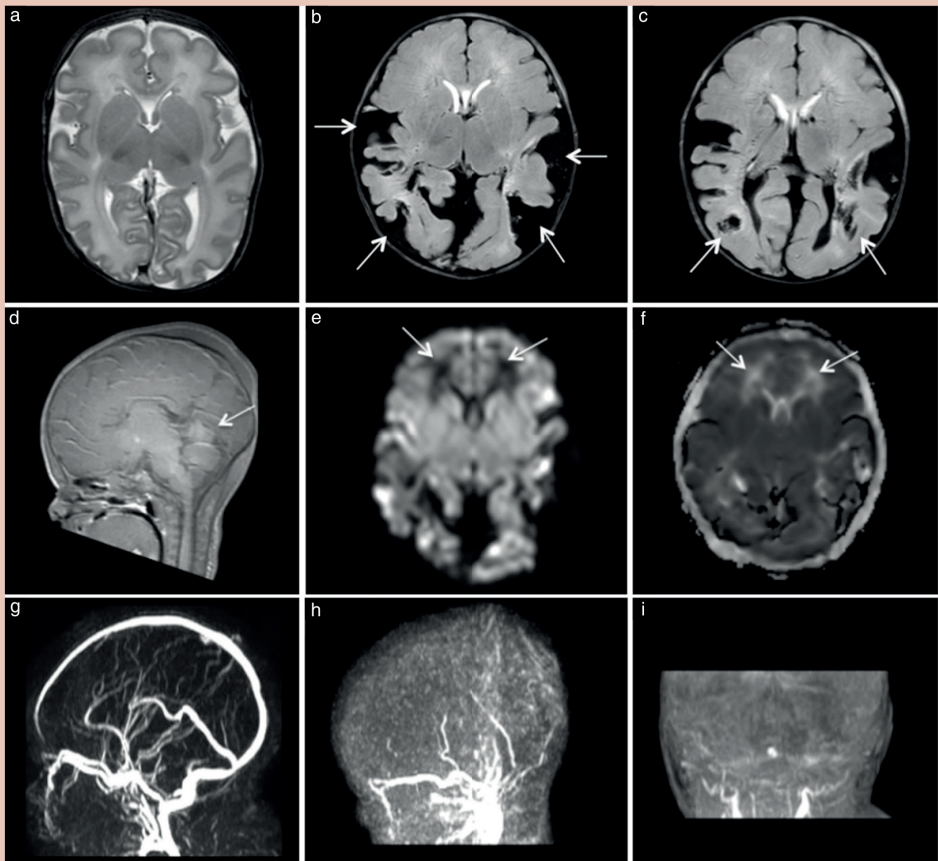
Magnetic resonance imaging in a case of twin anemia-polycythemia sequence. (a–c) Axial T2-weighted images of healthy donor twin (a) and recipient twin (b, c). Bilateral extra- and intracerebral hemorrhage filling all sulci and fissures and compressing both hemispheres can be seen in recipient (b, arrows), as well as a complete loss of gray–white matter differentiation compared with donor twin. Parenchymal venous infarction can be seen in the occipitotempoparietal regions (c, arrows). (d) Sagittal T1-weighted image of recipient twin showing supratentorial blood (arrow) in posterior fossa, compressing cerebellum. (e) Diffusion-weighted image of recipient twin showing diffusely increased signal intensity over almost the whole slice, compatible with loss of gray–white matter differentiation on T1- and T2-weighted images, with only a small amount of relatively normal signal tissue (arrows). (f) Same slice as in (e) of apparent diffusion coefficient map with decreased intensity in same areas (arrows). Magnetic resonance venography in a normal neonatal brain (g) and in recipient twin (h), showing clear loss of venous and arterial cerebral blood flow in recipient twin, as is also seen on magnetic resonance angiography (i).
